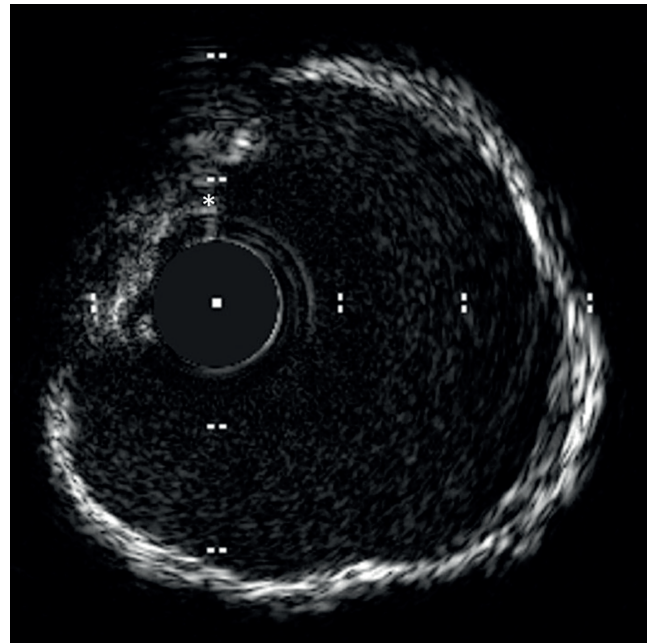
Superficial,  $360^\circ$  calcification, wire artifact (white asterisk) – intravascular ultrasound
